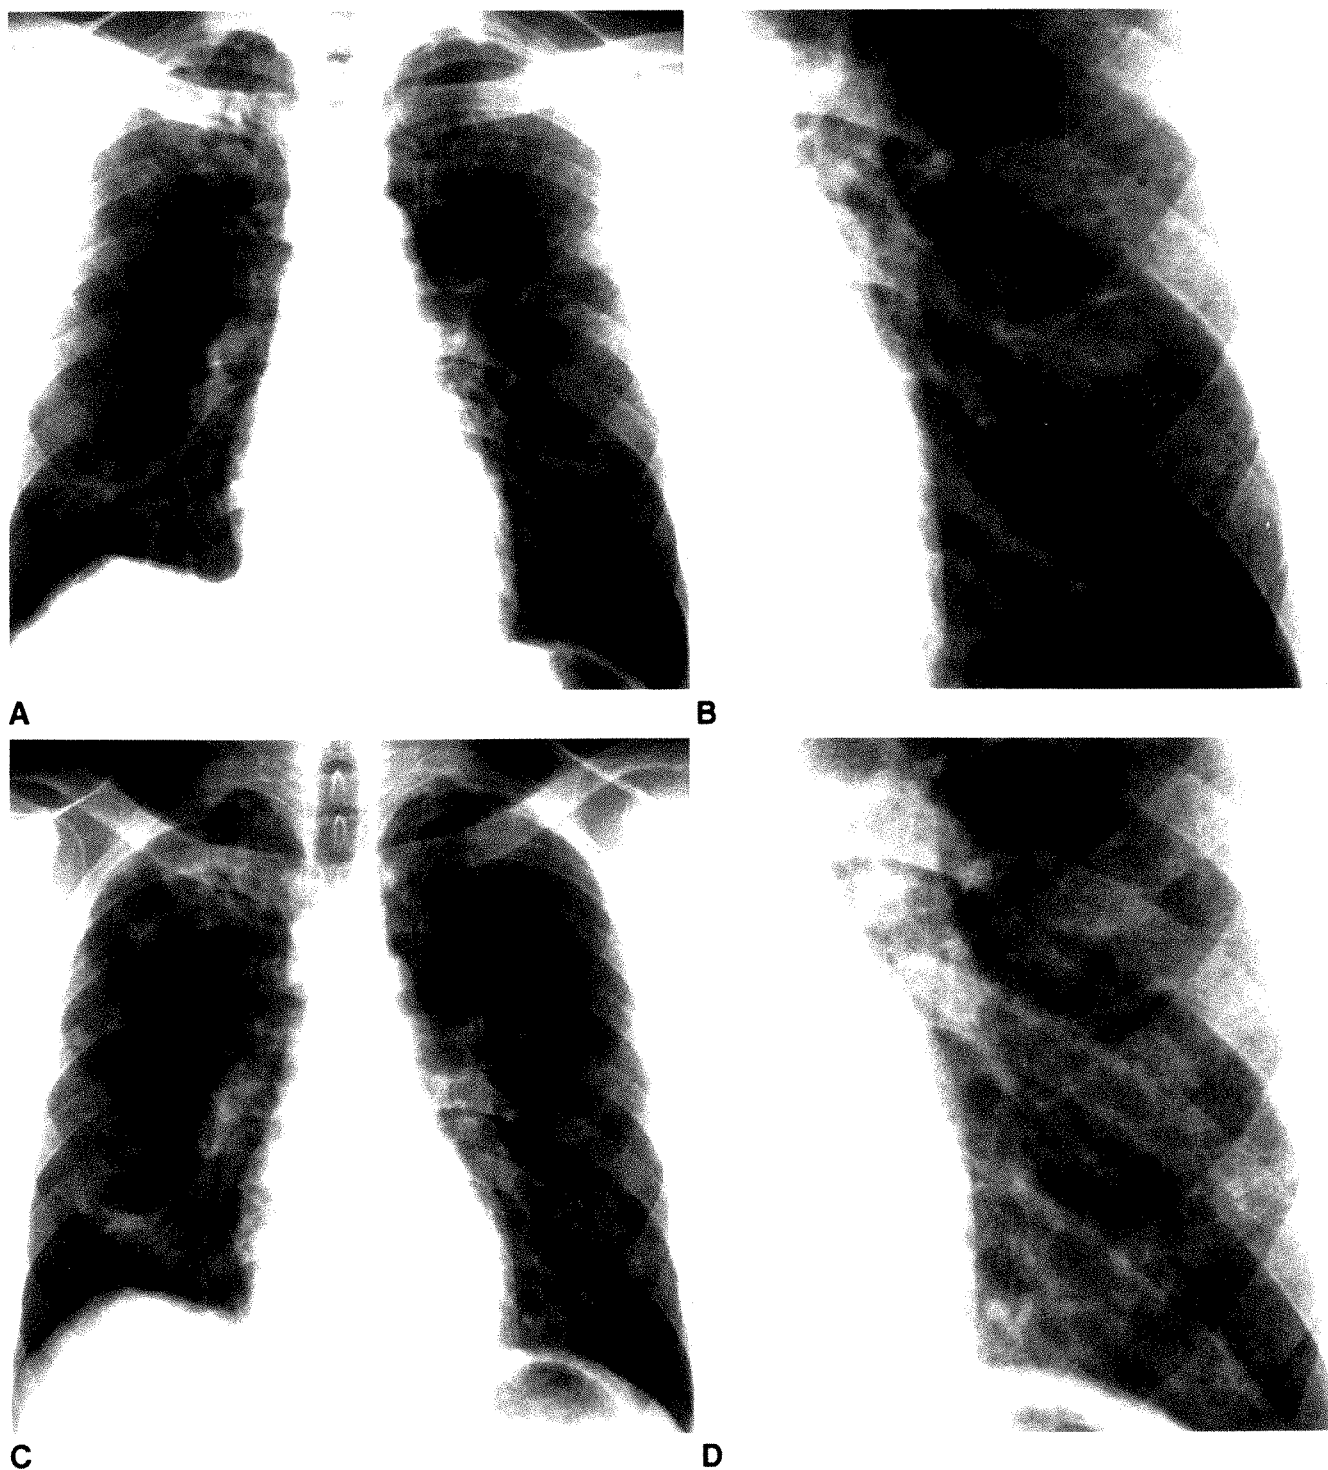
A–D, Chest radiographs in a 30-year-old patient with sarcoidosis show development of alveolar infiltrates related to corticosteroid withdrawal. Radiograph (A) and enlargement of part of left lung (B) made before corticosteroid withdrawal show hilar adenopathy and reticulonodular infiltrate consistent with stage 2 sarcoidosis. Subsequent radiograph (C) and enlargement of part of left lung (D) made during corticosteroid withdrawal show development of an alveolar pattern infiltrate.
